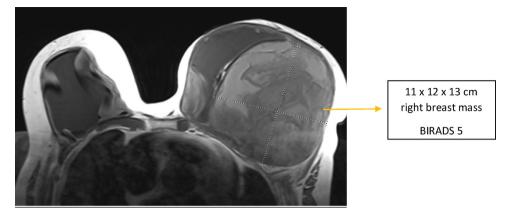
Noncontract MRI of the breast on initial presentation.
